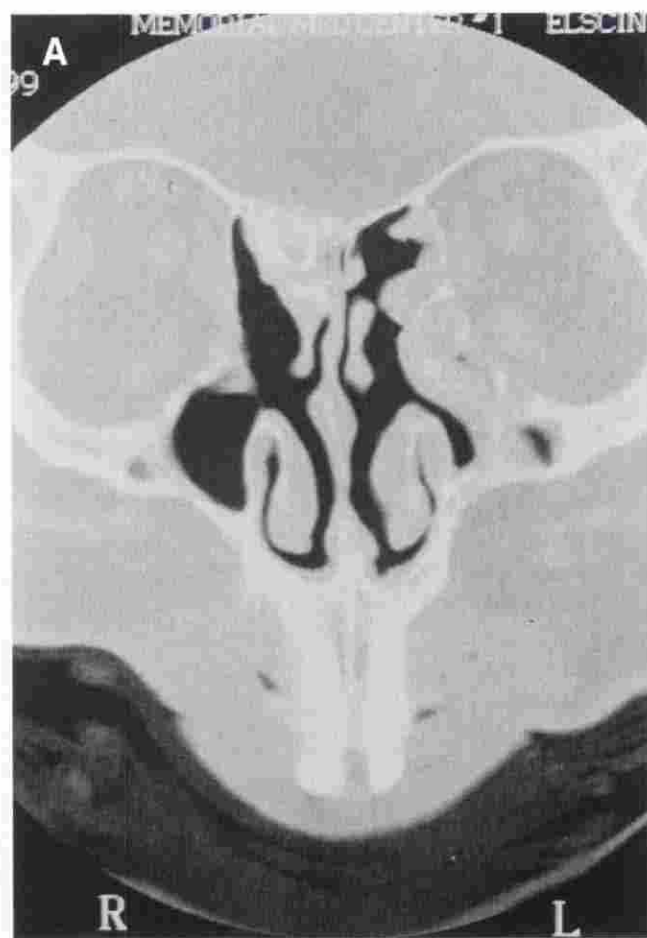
CT showing tumor on an (A) coronal plane and (B) on sagittal reconstruction.
